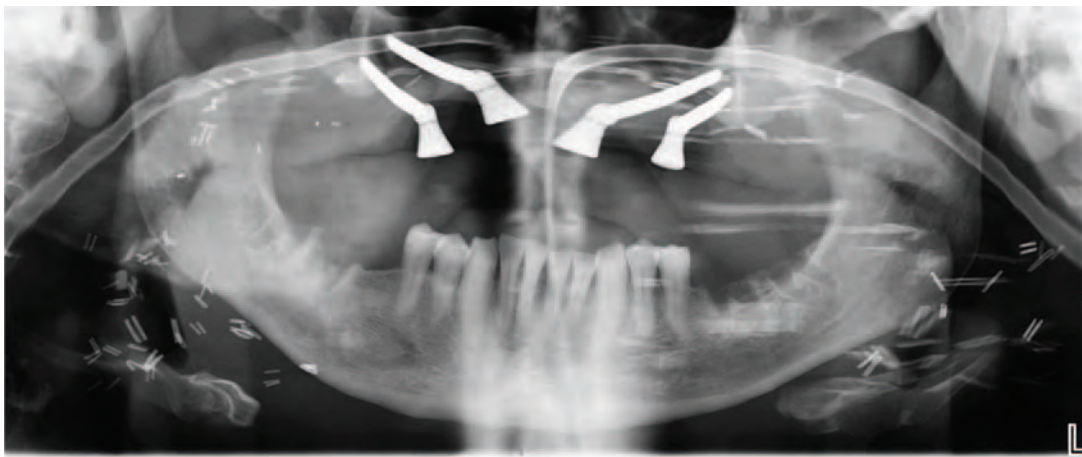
Orthopantomogram demonstrating position of zygomatic implants for patient A.
